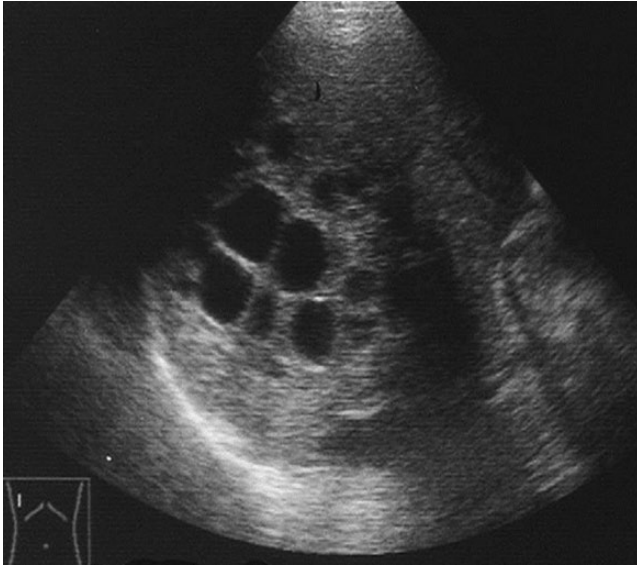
Liver hydatid cyst appearance on ultrasound; multiple daughter cysts are visible near the surface and posterior calcified pericyst membrane. (From Beeching and Dassanayake 2016 [27]. Reproduced with permission of Elsevier.)
